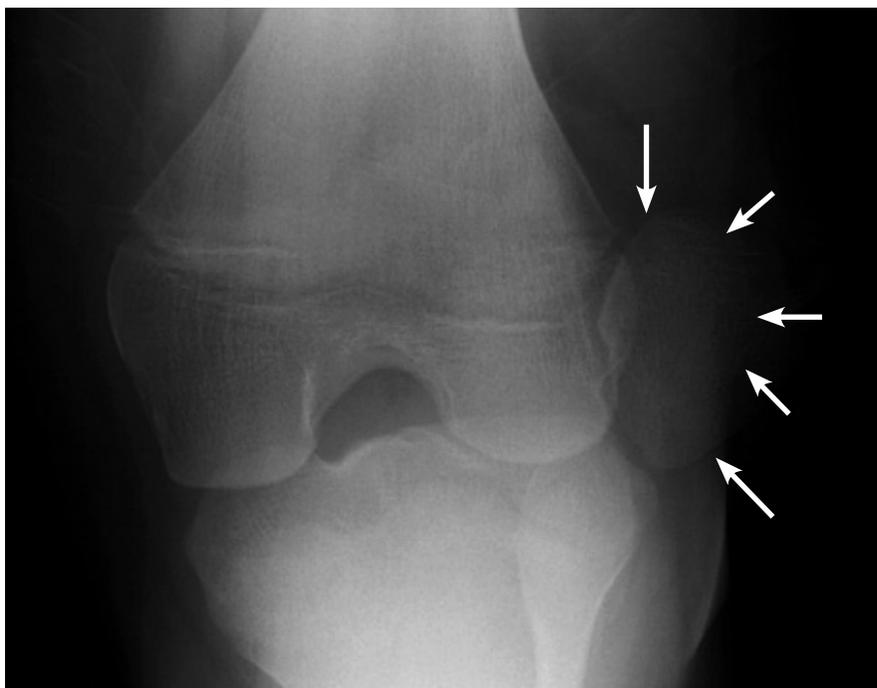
Radiograph of the knee, arrows show the laterally dislocated patella
